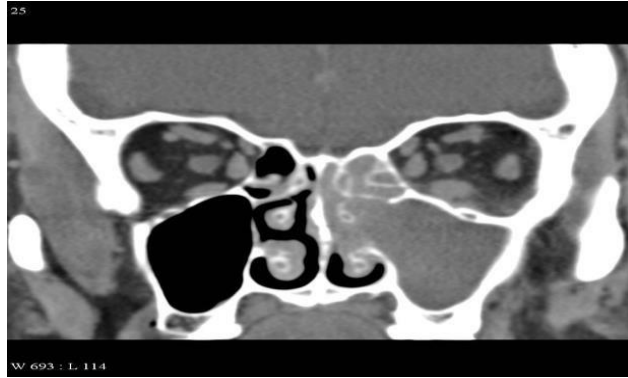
coronal CT image with acute sinusitis in Lt ethmoid and maxillary (<https://radiopaedia.org>)
